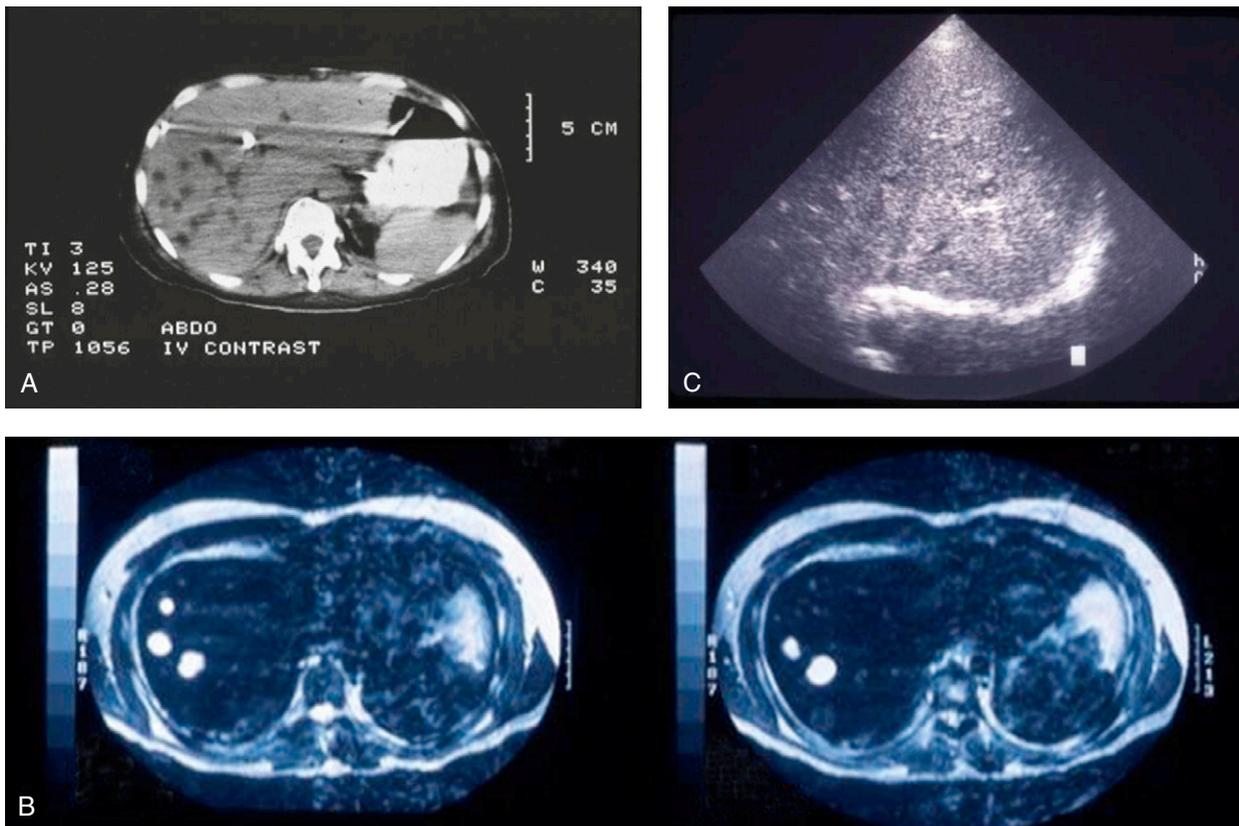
Liver *Candida* abscesses in patients with chronic disseminated candidiasis. (A) CT scan of liver showing multiple hypoechoic lesions. (B) MRI of the liver: note high-intensity foci of infection. (C) Ultrasound of the liver: bull's eye shown by arrow.
